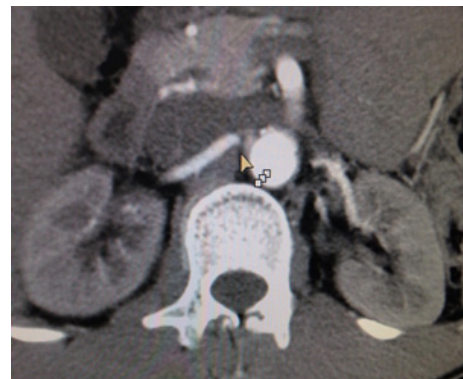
CT scan, axial view showing stenosis of the right renal artery (arrow). There was a filling defect occupying almost the entire ostium of the right renal artery.
